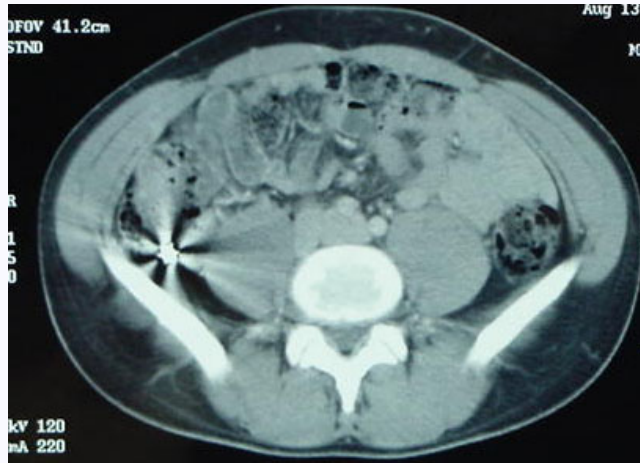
Bullet in caecal pole on CT abdomen.
